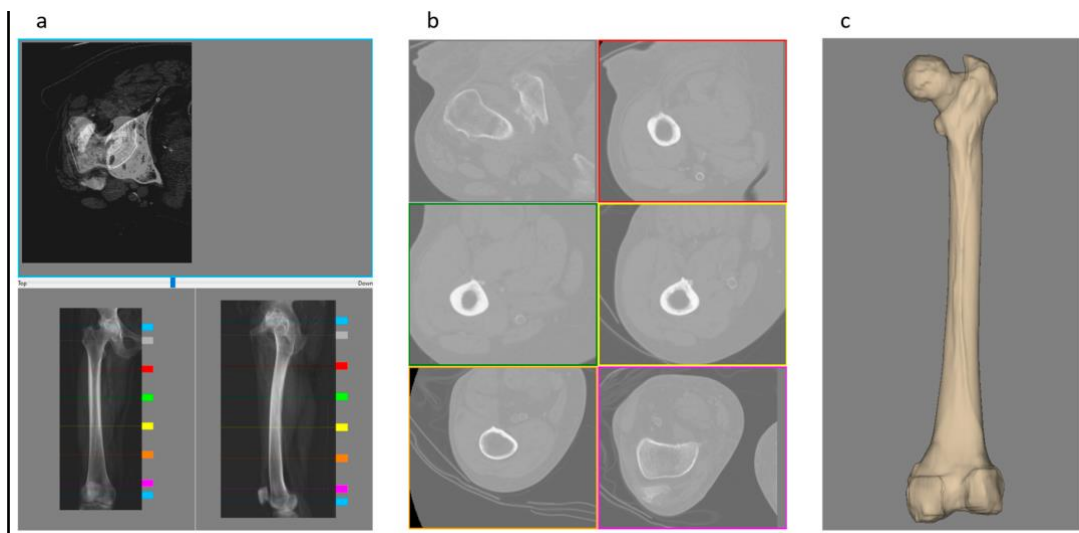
A virtual surgical plan was conducted by a surgeon based on the in-house software. The multimodal display principles. (a) The RX window where the CT dataset is represented as two orthogonal radiography projections: antero-posterior view (bottom left) and medio-lateral view (bottom right), together with a merged view (top) of two CT slices to visualise the femoral anteversion. The coloured sliders at the edge of the RX-projection image are used to choose the CT slices for the anteversion representation (blue sliders) and (b) the CT slices of the CT-window (sliders from grey to magenta); (c) the 3D-window, where the femoral bone is represented with a surface rendering. Reprinted from [215].
